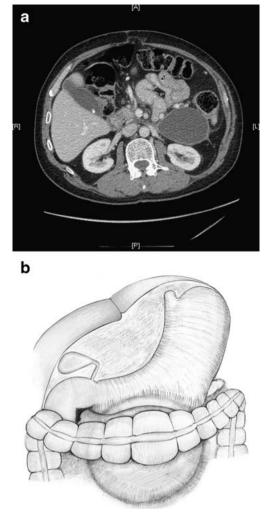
a, b This patient had a large PP that extended well into the infracolic compartment as shown in this CT section (a). The PP was readily visible within the infracolic compartment at laparoscopy (b) and was drained by cystjejunostomy.
